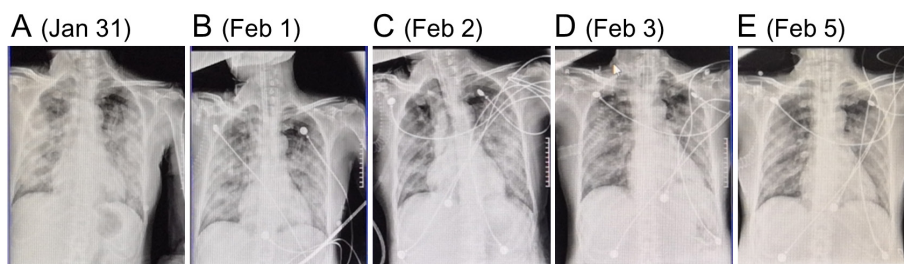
Posteroanterior chest radiographs of patient 4 obtained on January 31 (A), February 1 (B), February 2 (C), February 3 (D), and February 5 (E), 2020.
